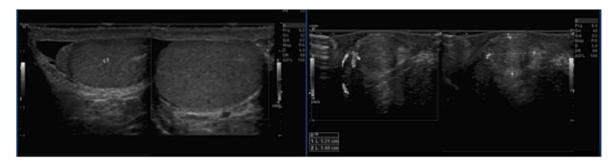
Scrotal ultrasound showed a rounded heterogenous mass at the tail of the epididymis, measuring about 1.6  $\times$  1.5 cm.
